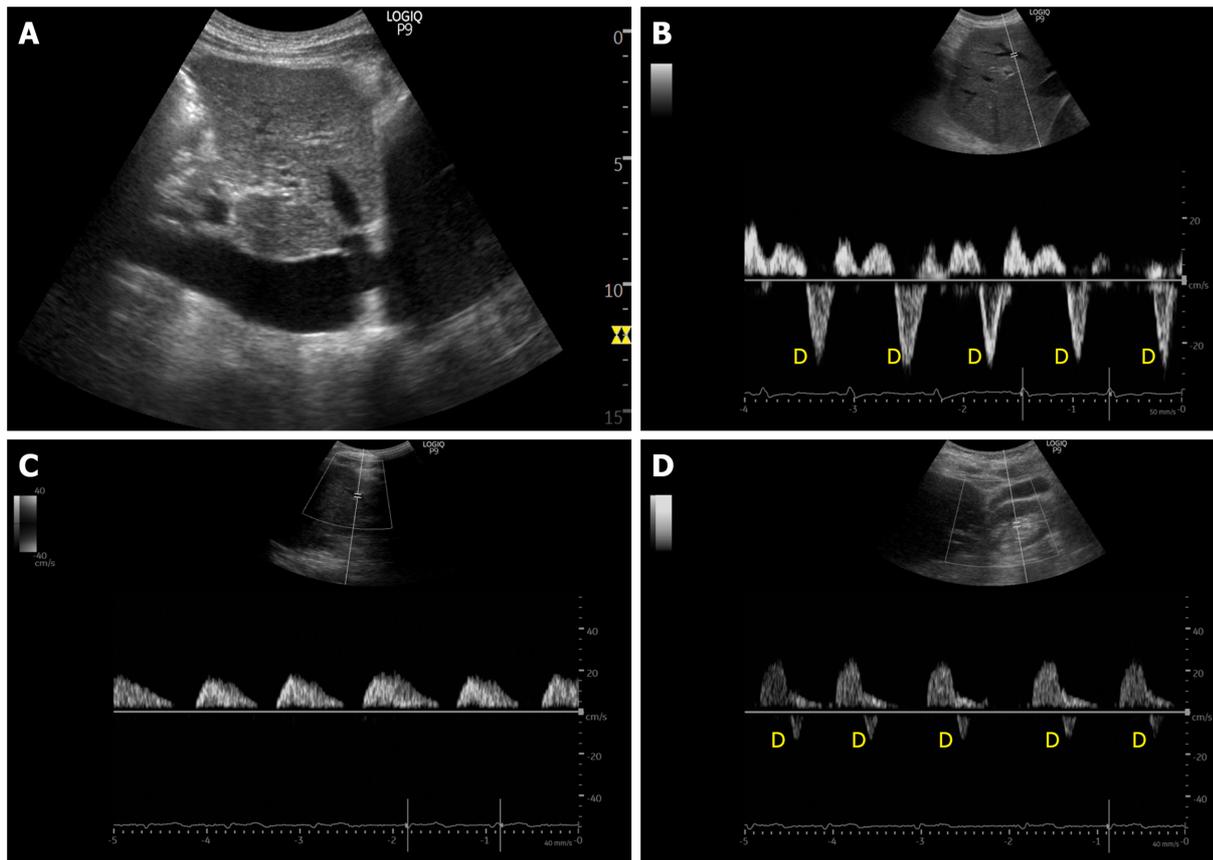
Example of ultrasound stigmata of severe venous congestion obtained from a patient with congestive heart failure exacerbation and tricuspid regurgitation. A: Dilated inferior vena cava; B: Hepatic vein Doppler demonstrating only D-wave below the baseline; C: Pulsatile portal vein with flow pauses in between the cardiac cycles; D: Ontra-renal vein demonstrating only D-wave below the baseline.
